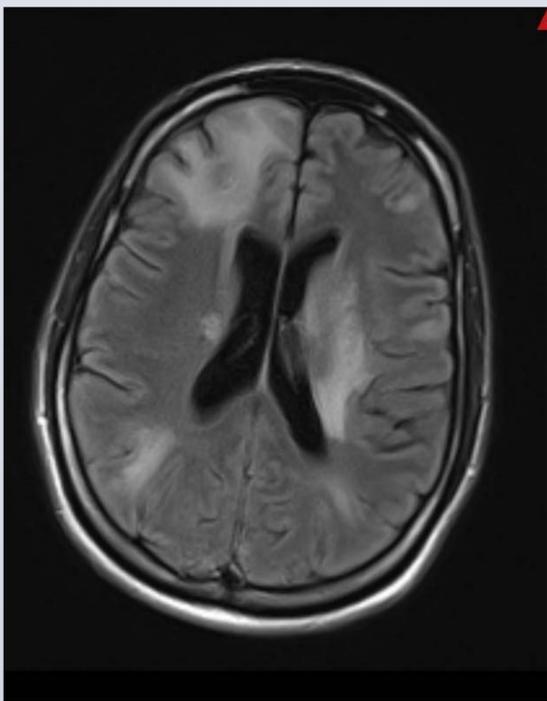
Axial T2 FLAIR MRI, with multiple regions of hyperintensity, the largest in the right frontal lobe, which also has an internal, circular, more hyperattenuating component. These lesions demonstrate mild mass effect.
